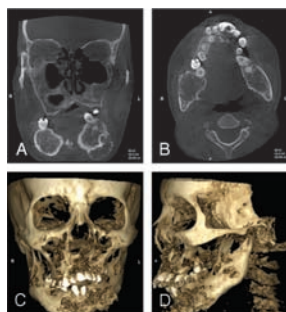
A and B, Dental volumetric computed tomographic scans show multiloculated lytic lesions affecting the body and rami of the mandible and maxilla on the coronal and axial sections. C and D, Three-dimensional reconstructed images show focal perforations in both jaws.
